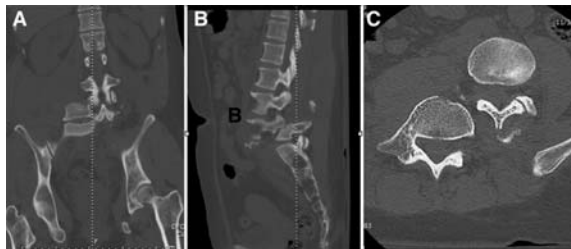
Computed tomography of the lumbosacral spine coronal view (A), sagittal view (B), and axial view (C) demonstrating the presence of total L4-L5 anterolateral dislocation with fracture of facet and transverse process and sign of double vertebral bodies.
